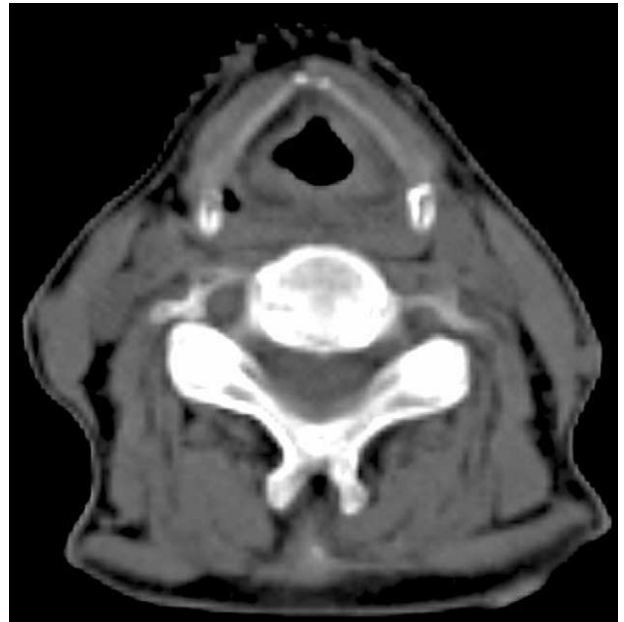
The throat CT before radiotherapy revealed the front part of left ventricular band was more hypertrophy than its right counterpart.
